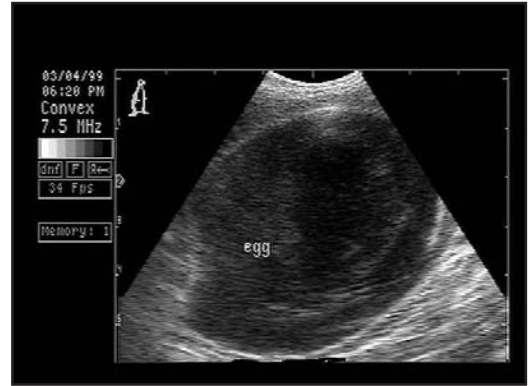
Coelomic ultrasound of the same cockatiel. Note the well-calcified egg in normal presentation for oviposition (7.5-MHz probe).
